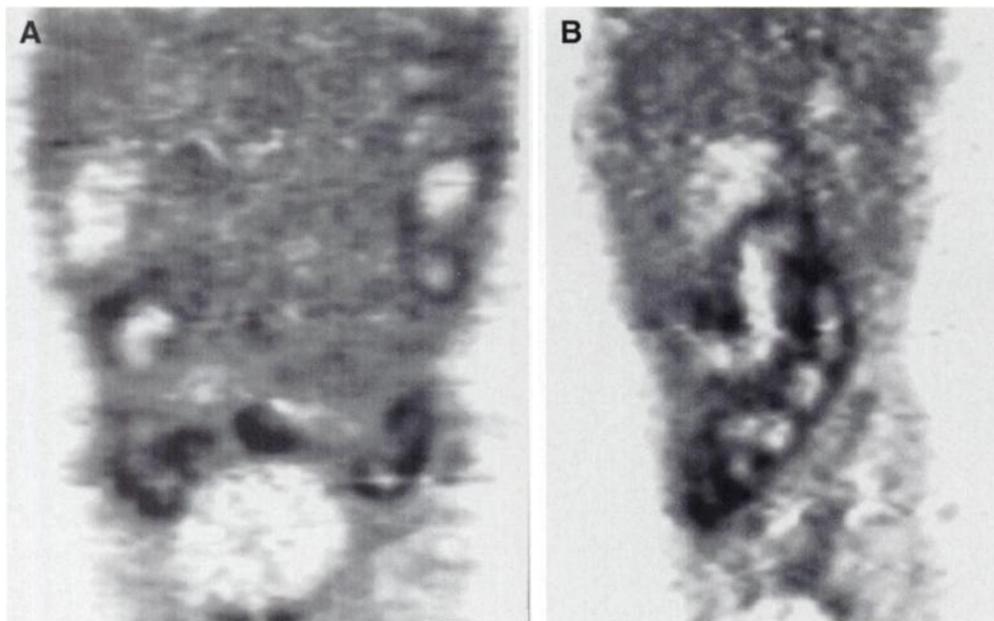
Coronal (A) and sagittal slice (B) of [¹⁸F]FDG PET images. Colon is dilated and there is marked [¹⁸F]FDG uptake in the colon wall (SUV = 2.1). Other slices showed that most of the length of the colon had this uptake. Background abdominal activity (SUV = 1.2) approximates that in the liver (SUV = 1.3). Patient had been diagnosed as having clostridium difficile toxin in the stool.
